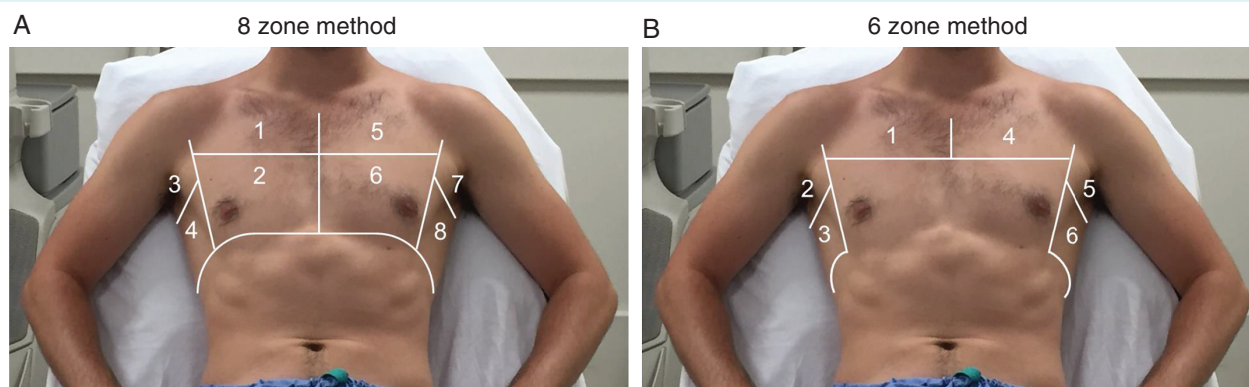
Example of eight (A) and six (B) chest zone protocol for lung ultrasound imaging. Adapted with permission from Platz *et al.*¹¹, Copyright (2017).
